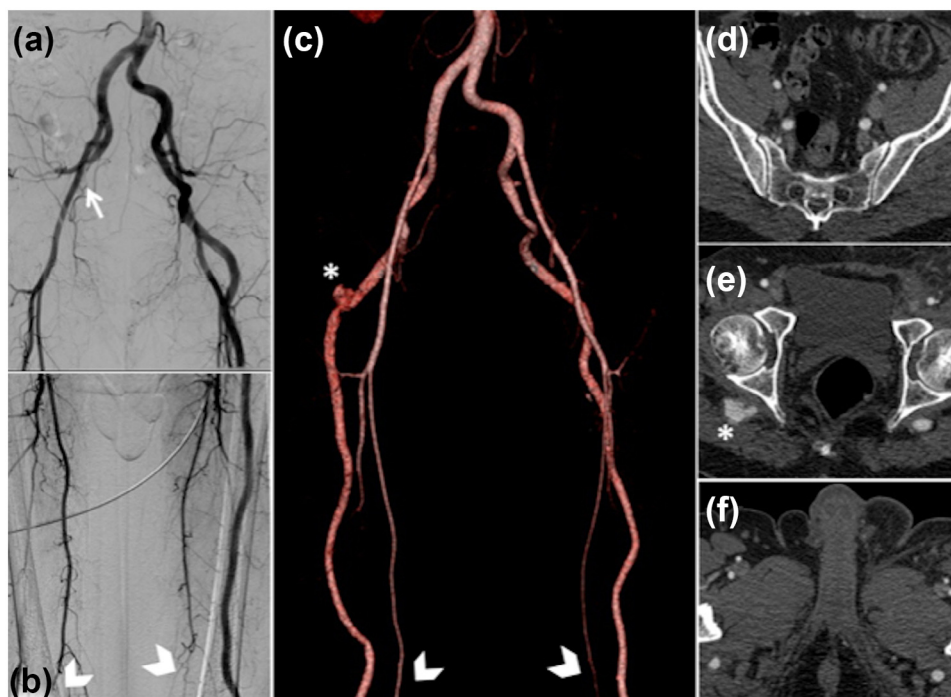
Persistent sciatic artery. (a, b) Digital subtraction angiography (DSA) showing bilateral persistent sciatic arteries with complete thrombosis of the persistent sciatic artery on the right (*white arrow*). Note the small distal superficial femoral arteries (*white arrowheads*). (c) Computerized tomography (CT) volume rendering technique (VRT) reconstructions performed following thrombolysis now showing both persistent sciatic arteries are patent unmasking the aneurysm of the right persistent sciatic artery, which was the cause of the thrombosis. Axial CT angiography images also following thrombolysis: (d) large internal iliac arteries in comparison to the external iliac arteries, the reverse of normal. (e) The aneurysm of the right persistent sciatic artery (*white asterisk*) and (f) the classic posterior location of the persistent sciatic arteries with small superficial femoral arteries.
